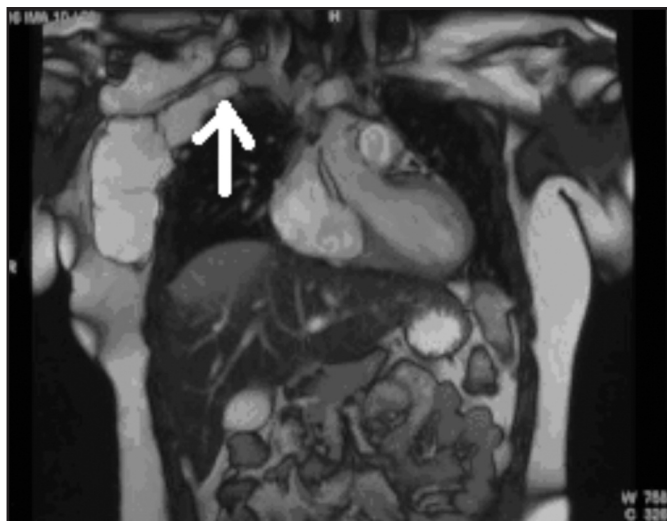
MRI image, There is encasement of the subclavian vessels and the subclavian vessels appear compressed by this lesion.
